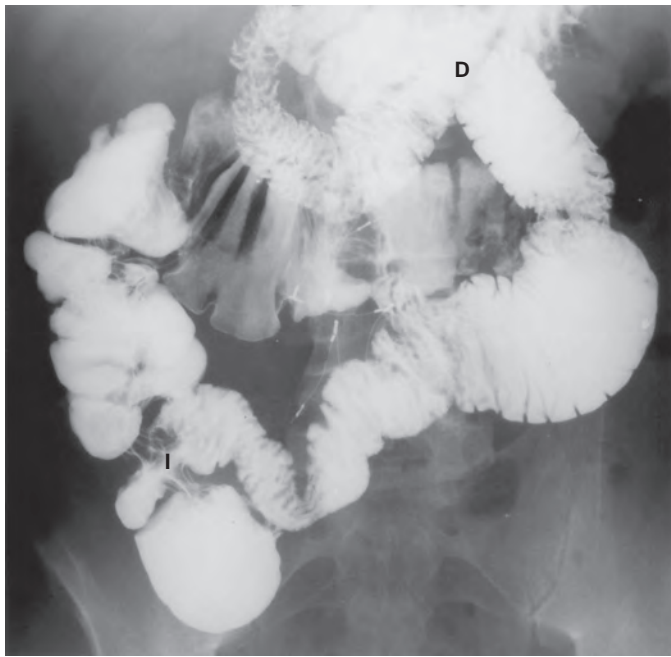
Short gut syndrome. This overhead radiograph shows a total of only three loops of small bowel from the duodenojejunal junction (D) to the ileocecal valve (I). The small bowel is dilated but not obstructed.
